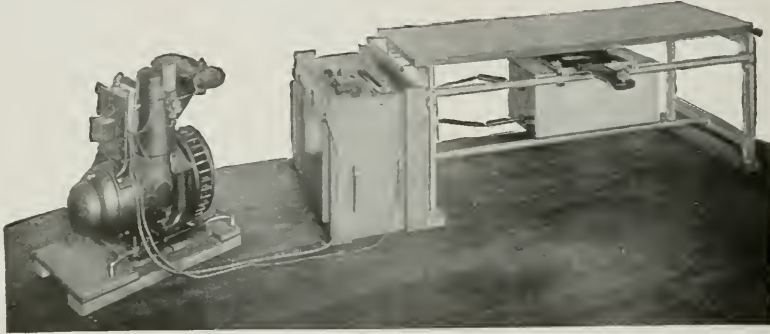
COMPLETE PORTABLE ROENTGEN RAY OUTFIT.
